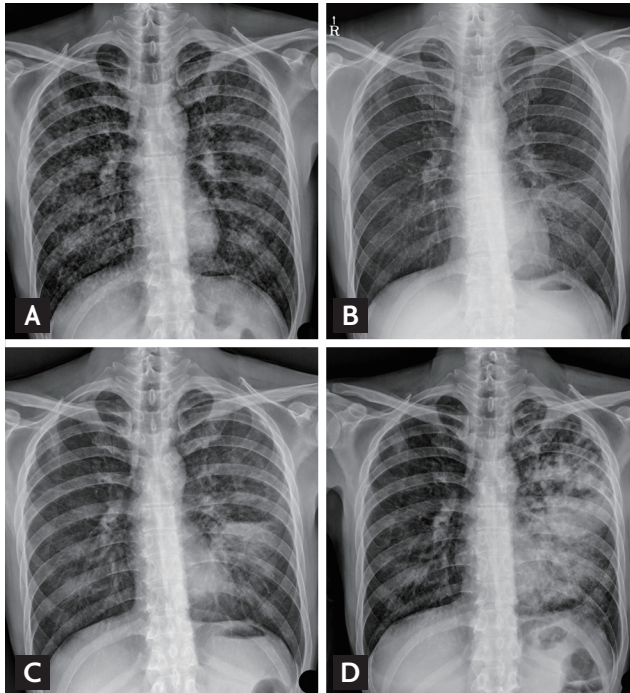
Chest radiographs. (A) Initial findings with multiple nodules in both lung fields. (B) Hospital day 19, showing improvement 12 days after administration of gefitinib. (C) Hospital day 20, showing pneumonic infiltration in the left upper lung field. (D) Hospital day 25, showing aggravation of consolidation on left lung.
